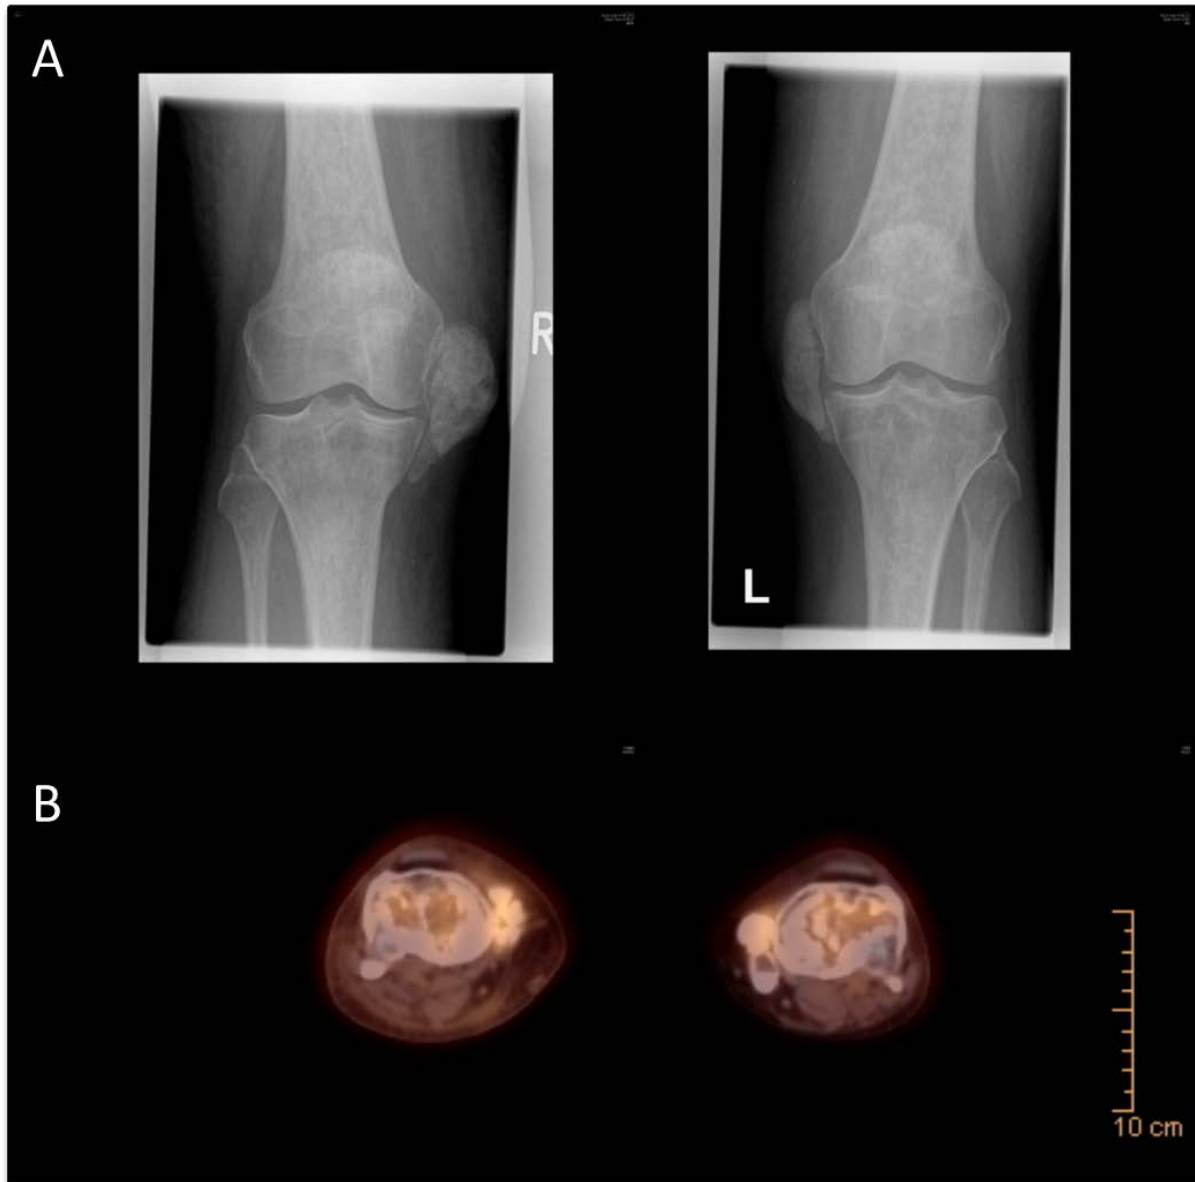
Roentgenograms of both knees (1A). Striking are the medial tumorous calcifications adjacent to the knee joints bilaterally. No changes consistent with calcium pyrophosphate deposition could be found. (1B). Computerized positron emission tomography (PET-CT) with contrast of knee joints. Markedly enhanced glucose metabolism localized to soft-tissue excrescences medial to both knees, although enhancement is also evident in the proximal tibia bilaterally.
